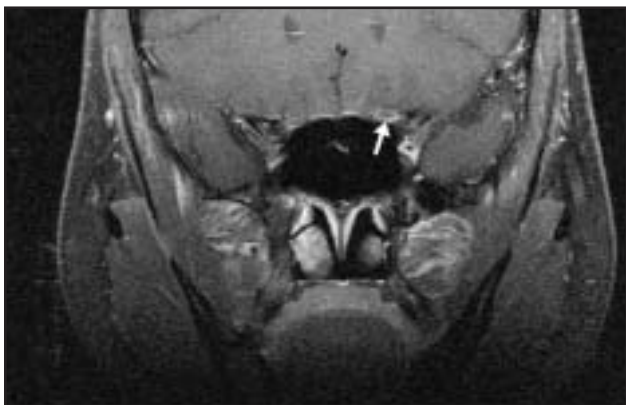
Left intracanalicular optic nerve sheath meningioma. A T1-weighted, contrast-enhanced coronal MRI shows growth of the meningioma within the left optic canal (arrow).
